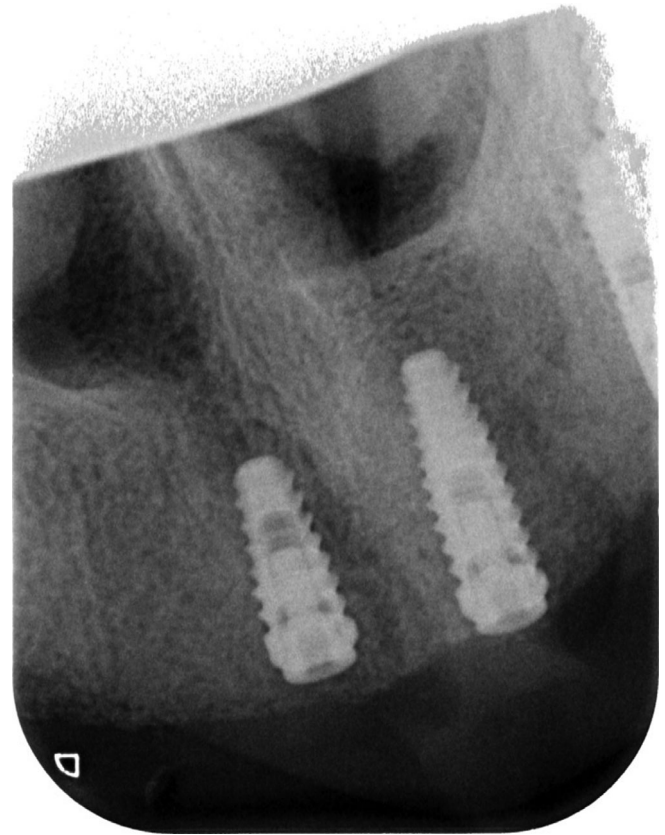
Endoral X-ray showing the replaced shorter implant not intersecting the course of Canalis Sinuosus (CS)
